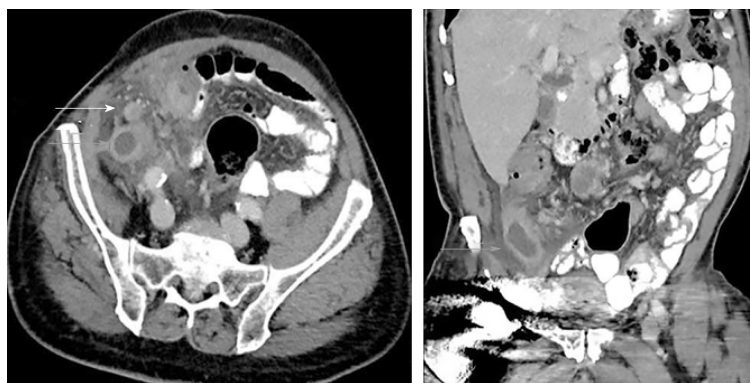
Axial and coronal abdominal contrast enhanced computed tomography images depict a fluid filled and dilated appendix (gray arrows) and adenopathy (white arrow). Surrounding inflammatory changes present.
